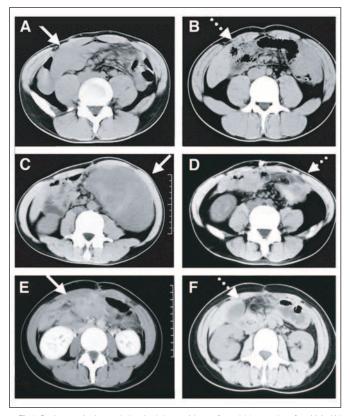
Patient 1: An intra-abdominal desmoid was found 39 months after IAA. (A) CT scan before DOX/DTIC therapy showing a large mass the in abdomen. (B) CT scan of the same patient after DOX/DTIC therapy, showing CR with no residual tumor. Patient 2: A pelvic desmoid was found 20 months after IAA. (C) CT scan before DOX/DTIC therapy showing a large mass in the pelvis. (D) CT scan of the same patient after DOX/DTIC therapy, showing only scarring and fibrosis of CR with no residual tumor. Patient 3: An intra-abdominal desmoid was found 17 months after IAA. (E) CT scan before DOX/DTIC therapy showing a large mass in the abdomen. (F) CT scan of the same patient after DOX/DTIC therapy, showing CR with no residual tumor. IAA, ileal J-pouch anal anastomosis; DOX, doxorubic cin; DTIC, dacarbazine; CT, computed tomography; CR, complete remission.
